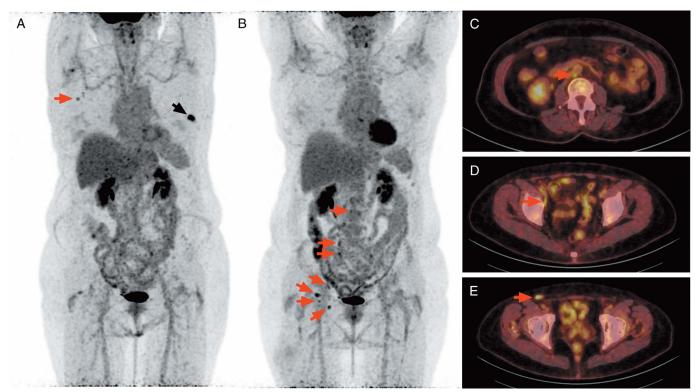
Since the launch of large-scale COVID-19 vaccination, <sup>18</sup>F-FDG uptake in reactive axillary lymph nodes (LNs) is frequently observed in PET/CT studies. <sup>1-7</sup> A 74-year-old woman underwent <sup>18</sup>F-FDG PET/CT for staging of left breast cancer 2 weeks after receiving the first dose of the Oxford-AstraZeneca COVID-19 vaccination in the right arm. <sup>18</sup>F-FDG PET/CT showed high uptake in the primary tumor (A, black arrow) without signs of LN or distant metastasis and moderate LN uptake in the right axilla related to vaccination (A, red arrow). After 3 cycles of neoadjuvant chemotherapy and 7 days after repeat Pfizer-BioNTech COVID-19 vaccine in the right thigh, she underwent <sup>18</sup>F-FDG-PET/CT for response evaluation. Complete metabolic response was observed for the primary tumor, but <sup>18</sup>F-FDG uptake was observed in nonenlarged right-sided inguinal, iliac, and para-aortic LNs related to the vaccination in the thigh (B–E, red arrows). In patients who previously received COVID-19 vaccine in the deltoid muscle, PET/CT studies can show <sup>18</sup>F-FDG-positive LNs in the ipsilateral axilla that should not be mistaken for cancer, highlighting the need for the nuclear medicine physician to check timing and side of prior vaccination. The thigh can be used as an alternate injection site, for example in case of lymphedema in both arms. <sup>8</sup> COVID-19 vaccination in the thigh might also be an option for adequate axillary staging in patients with breast cancer. <sup>9,10</sup> Physicians should be aware of the previously described <sup>18</sup>F-FDG uptake pattern in the subdiaphragmatic LN chains that vaccination in the thigh may provoke.
